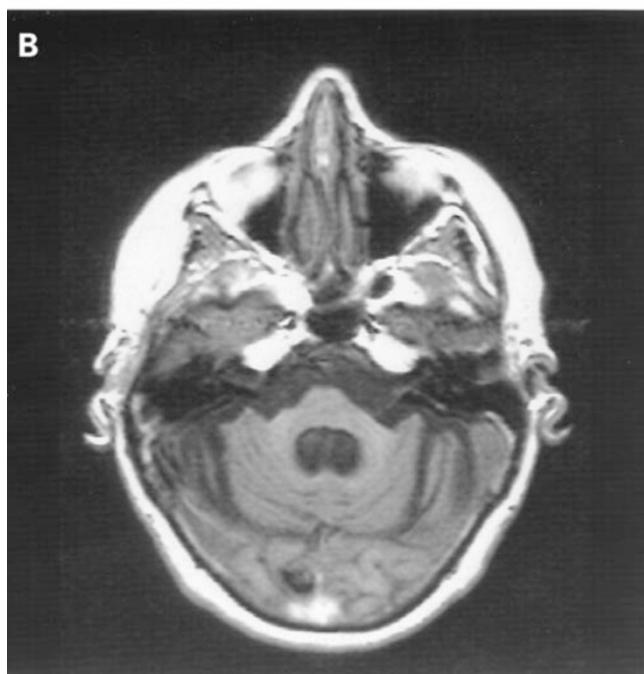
Cephalic MRI of a SCA2 patient with 10 years' disease. A Sagittal plane, inversion Recovery T2 weighted (TR = 5000 ms, TE = 17 ms, TI = 140 ms) showing a global atrophy of the pons, predominantly posterior, associated to a discrete bulbar and cerebellar vermician superior atrophy. B Spin Echo T1 weighted (TR = 2000 ms, TE = 11 ms, TI = 800 ms) image on axial section through the middle of the pons showing its atrophy as well as on the cerebellar hemispheres associated with the dilatation of the fourth ventricle. (by permission of Dr Ayman Tourbah)
